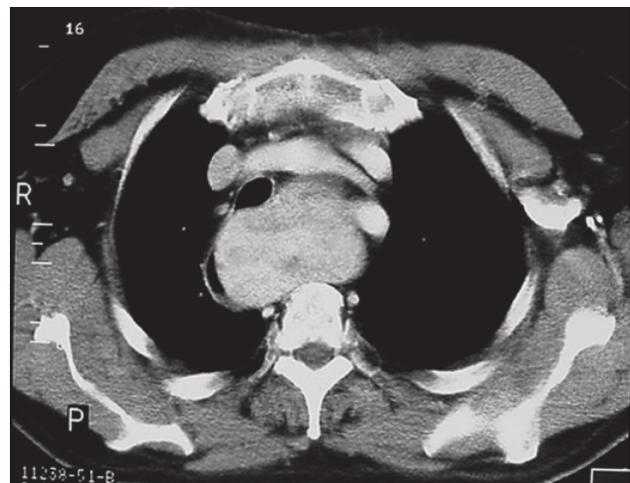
Neck and chest computed tomography (CT) after intravenous contrast medium enhancement reveals enlarged paratracheal mass.
